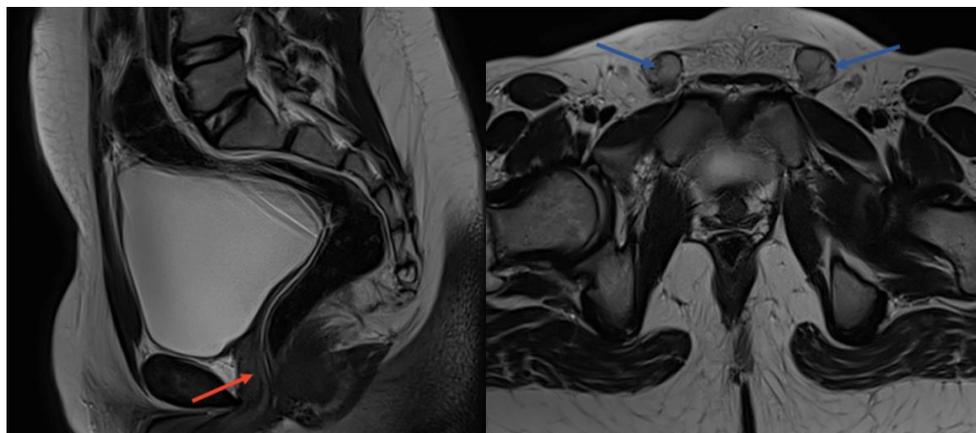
MRI with sagittal T2 (a), axial T2 (b) image: Absence of uterus and ovaries (red arrow) with testes in the inguinal canals (blue arrow)
